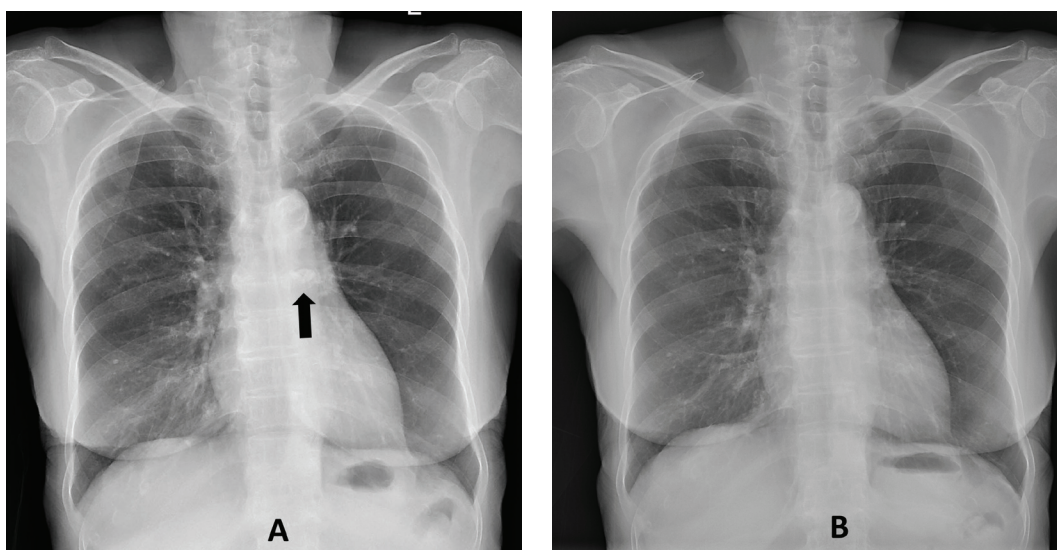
A. Before therapeutic bronchoscopy, a tiny radiopaque lesion at the left main bronchus. B. After therapeutic bronchoscopy, the broncholith vanished from the chest radiography.
